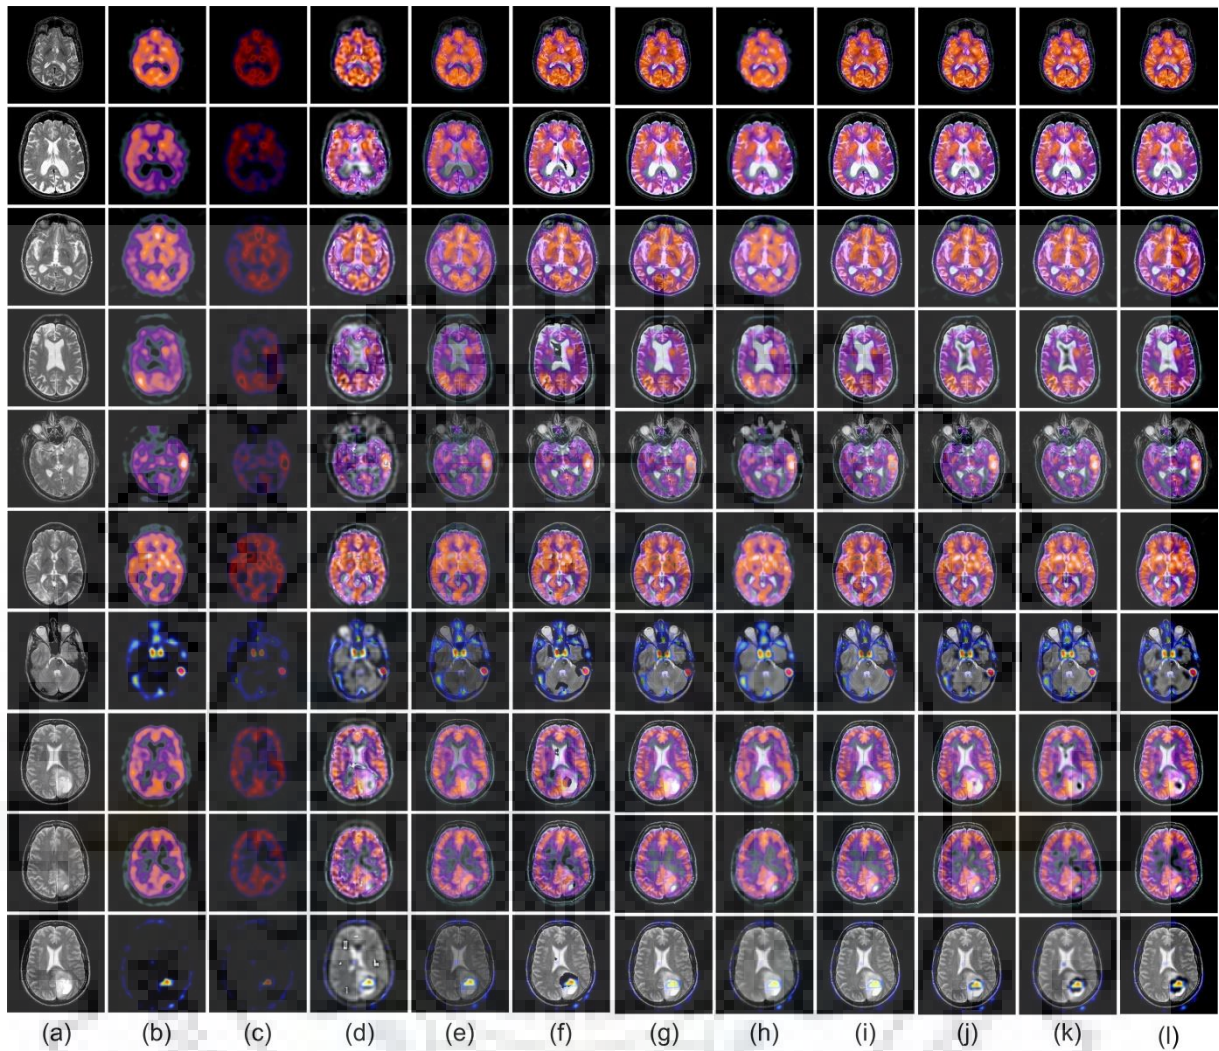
Multimodal fusion results of real neurological (a) MR images (b) SPECT image, fused images obtained by the (c) Method 1 (d) Method 2 (e) Method 3 (f) Method 4 (g) Method 5 (h) Method 6 (i) Method 7 (j) Method 8 (k) Method 9 (l) Method 10
